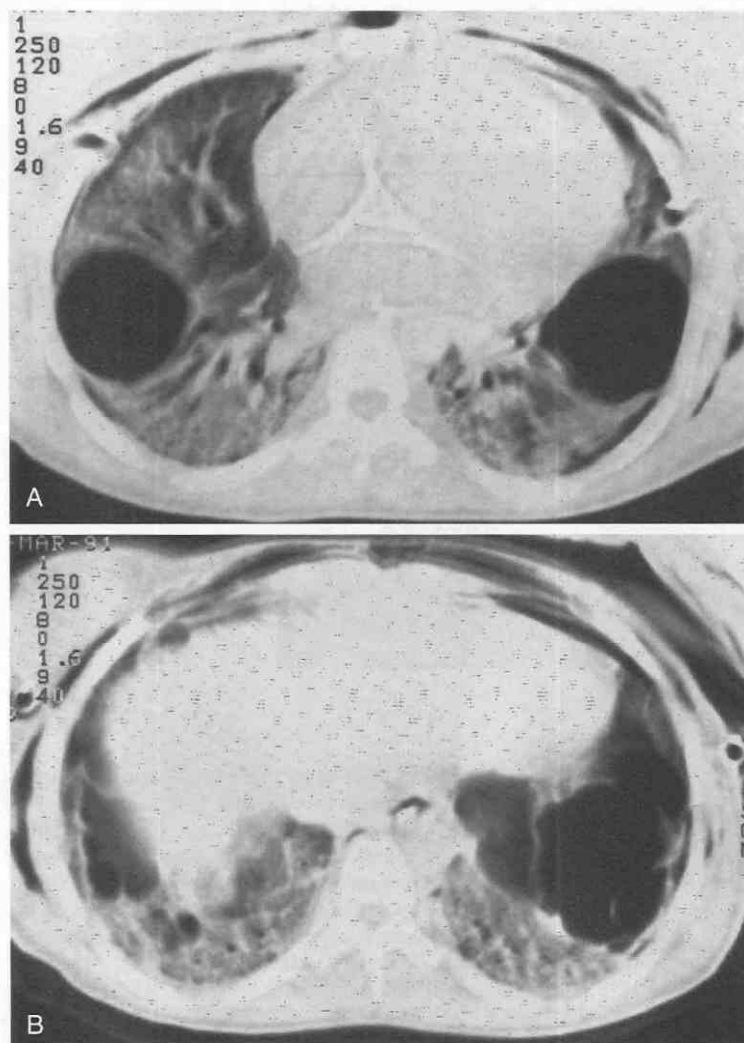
A and B, High-resolution CT of adult respiratory distress syndrome (ARDS) and its complications. Postpartum pneumonia and ARDS developed in a 17-year-old girl. Bilateral "ground-glass" infiltrates compatible with a diagnosis of ARDS are evident on CT scanning. Large extra-alveolar air cysts have developed. CT shows that these air cysts have no discernible walls and are located in the subpleural and basal regions of the lung. Bilateral chest tubes are in place for complicating pneumothoraces. Subcutaneous emphysema is present.
